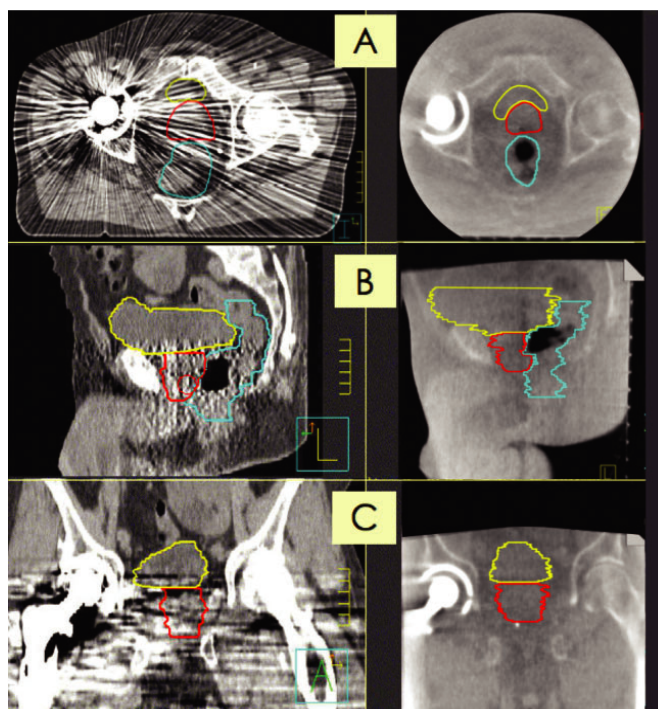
Segmentation of the bladder, prostate and rectum using the conventional CT (left) and the megavoltage cone beam CT (MV CBCT) (right) shown on the (A) axial, (B) sagittal and (C) coronal views.
